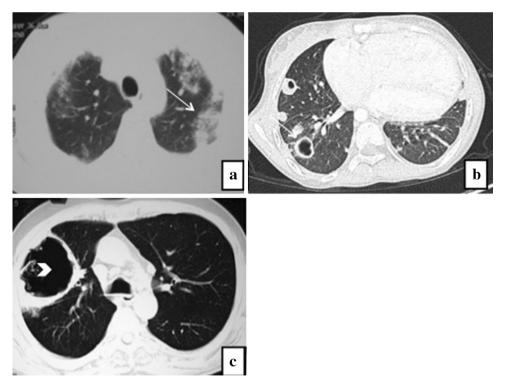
Staphylococcal pneumonia. a Chest CT shows coalescing peribronchial nodules with patchy consolidation in bilateral upper lobes c/w bronchopneumonia. b Multiple nodules with few of them show cavitation (*white arrow*) in right lung in a patient with septic embolism. c Chest CT shows well-defined large thin-walled air containing cyst likely pneumatocele (*arrowhead*)
